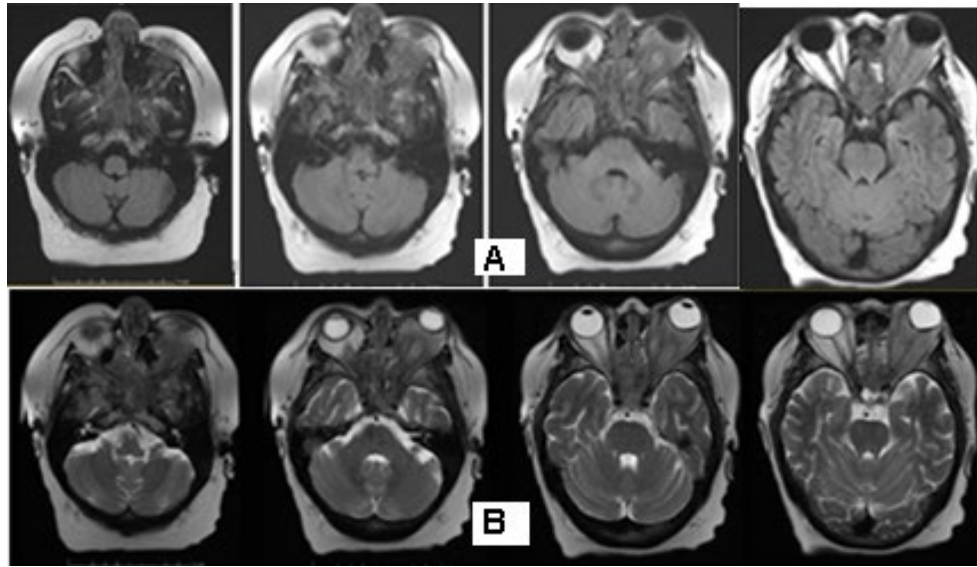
Axial MRI 3 months after the radiotherapy completion represent a tumor stationation without reduction or progression-A/ AxT2 FLAIR B/AxT2 FRFSE.
